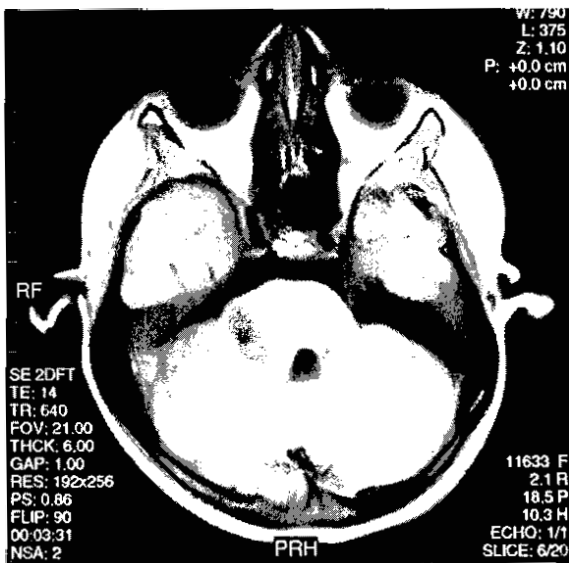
Case 2 at diagnosis: T1 weighted coronal MRI scan revealing a $2 \times 2 \times 1.8$ cm low-grade astrocytoma in far lateral aspect of pons extending into the right middle cerebellar peduncle. Mild mass effect with some effacement of the lateral ventricle.
